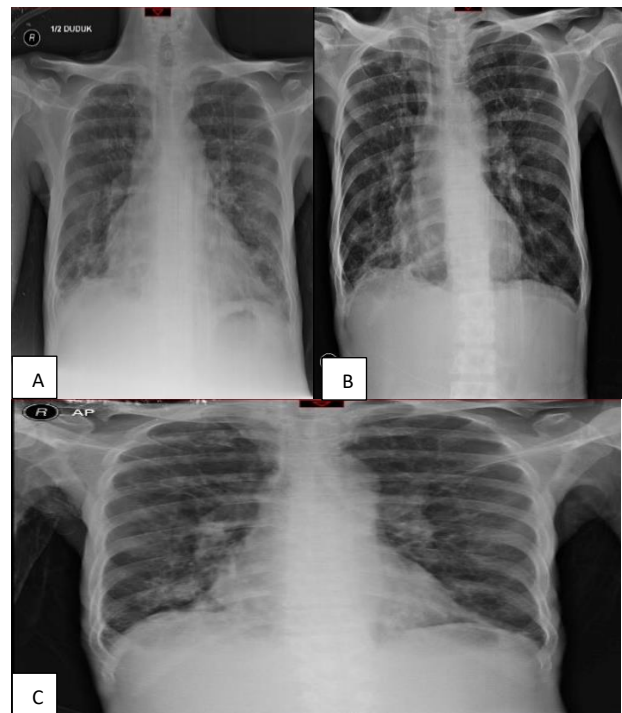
(A-C): Serial of chest x-ray.
